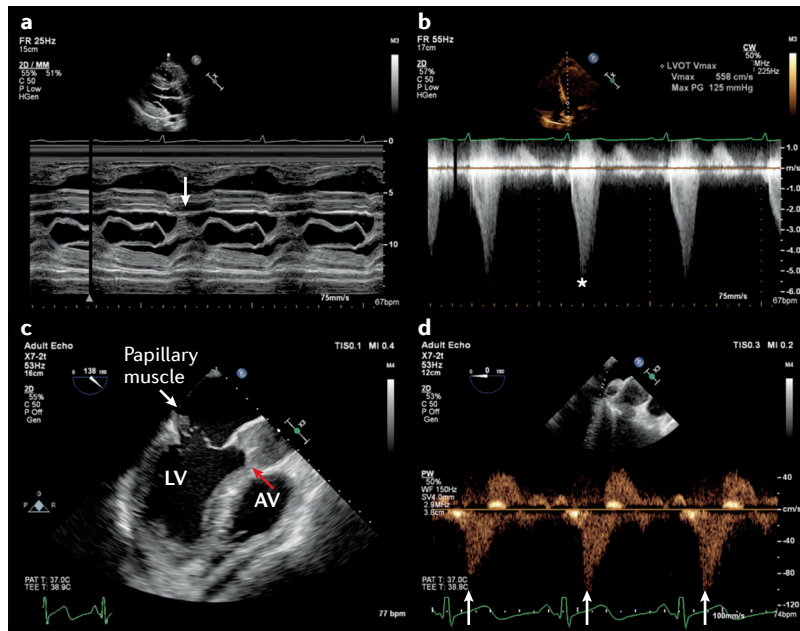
Echocardiographic features in patients receiving extracorporeal support. Transthoracic echocardiography in a patient with severe respiratory failure receiving venovenous extracorporeal membrane oxygenation (ECMO). a | Parasternal long axis M-mode echocardiography across the mitral valve showing systolic anterior motion of the mitral valve leaflets (arrow). b | This motion was associated with substantial left ventricular intracavity gradient of 125 mmHg (asterisk). c | A complication of ST-segment elevation myocardial infarction requiring peripheral ECMO is revealed on M-mode echocardiography; papillary muscle rupture had resulted in a flail anterior mitral valve leaflet (white arrow) with associated torrential mitral regurgitation. The increase in left ventricular afterload from ECMO has resulted in failure of the left ventricle (LV) to eject, with a persistently closed aortic valve (AV; red arrow) and stasis of blood in the aortic root. d | Reversal of systolic pulmonary venous flow (arrows) in a patient receiving peripheral venovenous ECMO, suggesting inadequate offloading of the LV.
